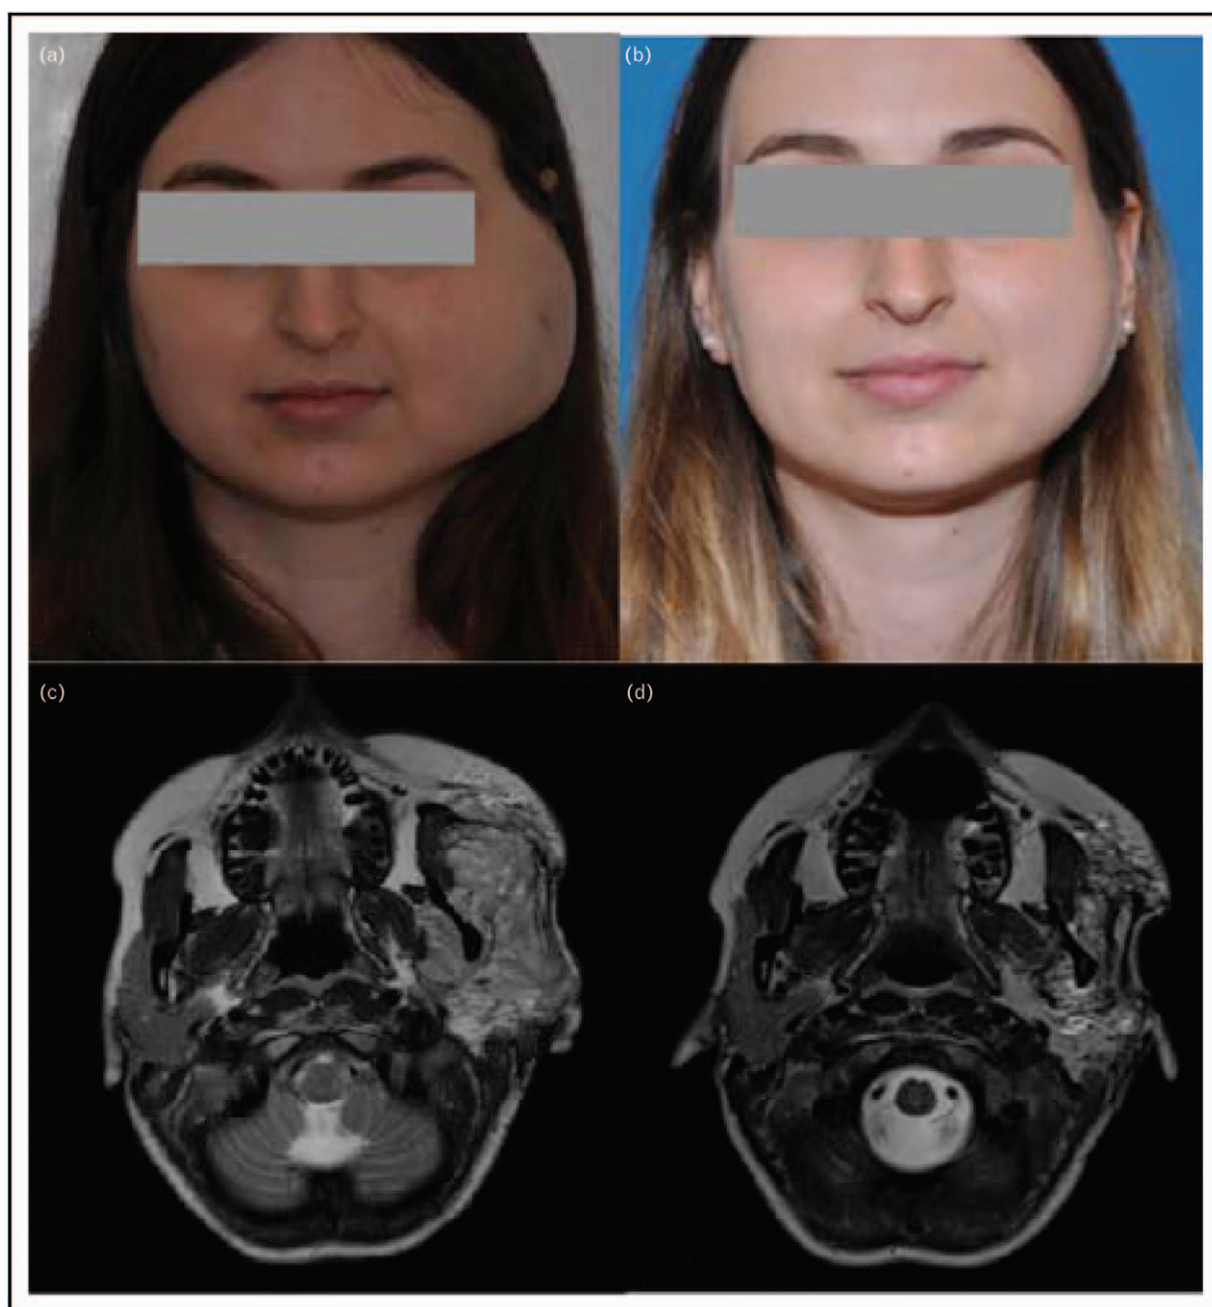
Decrease in size of left jugal venous malformation in a 29-year-old woman after 6 months of treatment with rapamycin. Bottom, MRI images.
